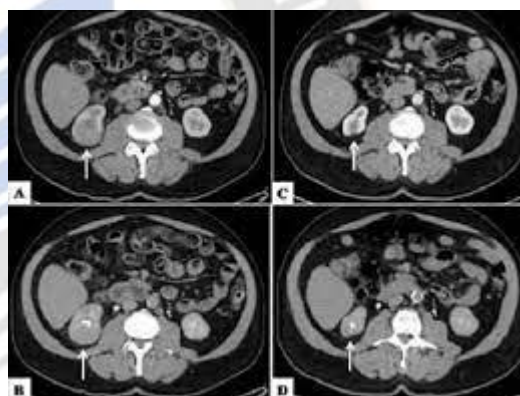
Image Enhancement of CT Kidney Cancer Images used for Classification
